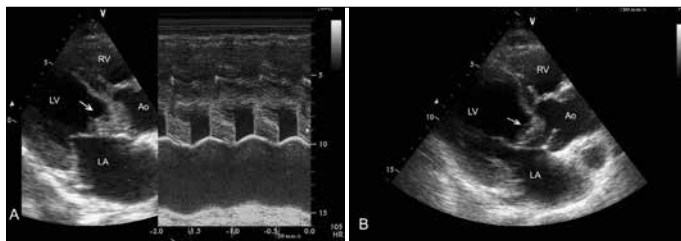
A) Transthoracic echocardiography (TTE): the parasternal long-axis view shows an aortic mass (white arrow) attached to right aortic cusp of the aortic valve. In M-mode echocardiography, this aortic mass fills the aortic orifice. B) Parasternal long-axis view of TTE after embolization, it is seen that the aortic mass (white arrow) has become smaller in size. It is also seen that this aortic mass prevents aortic valve closure
